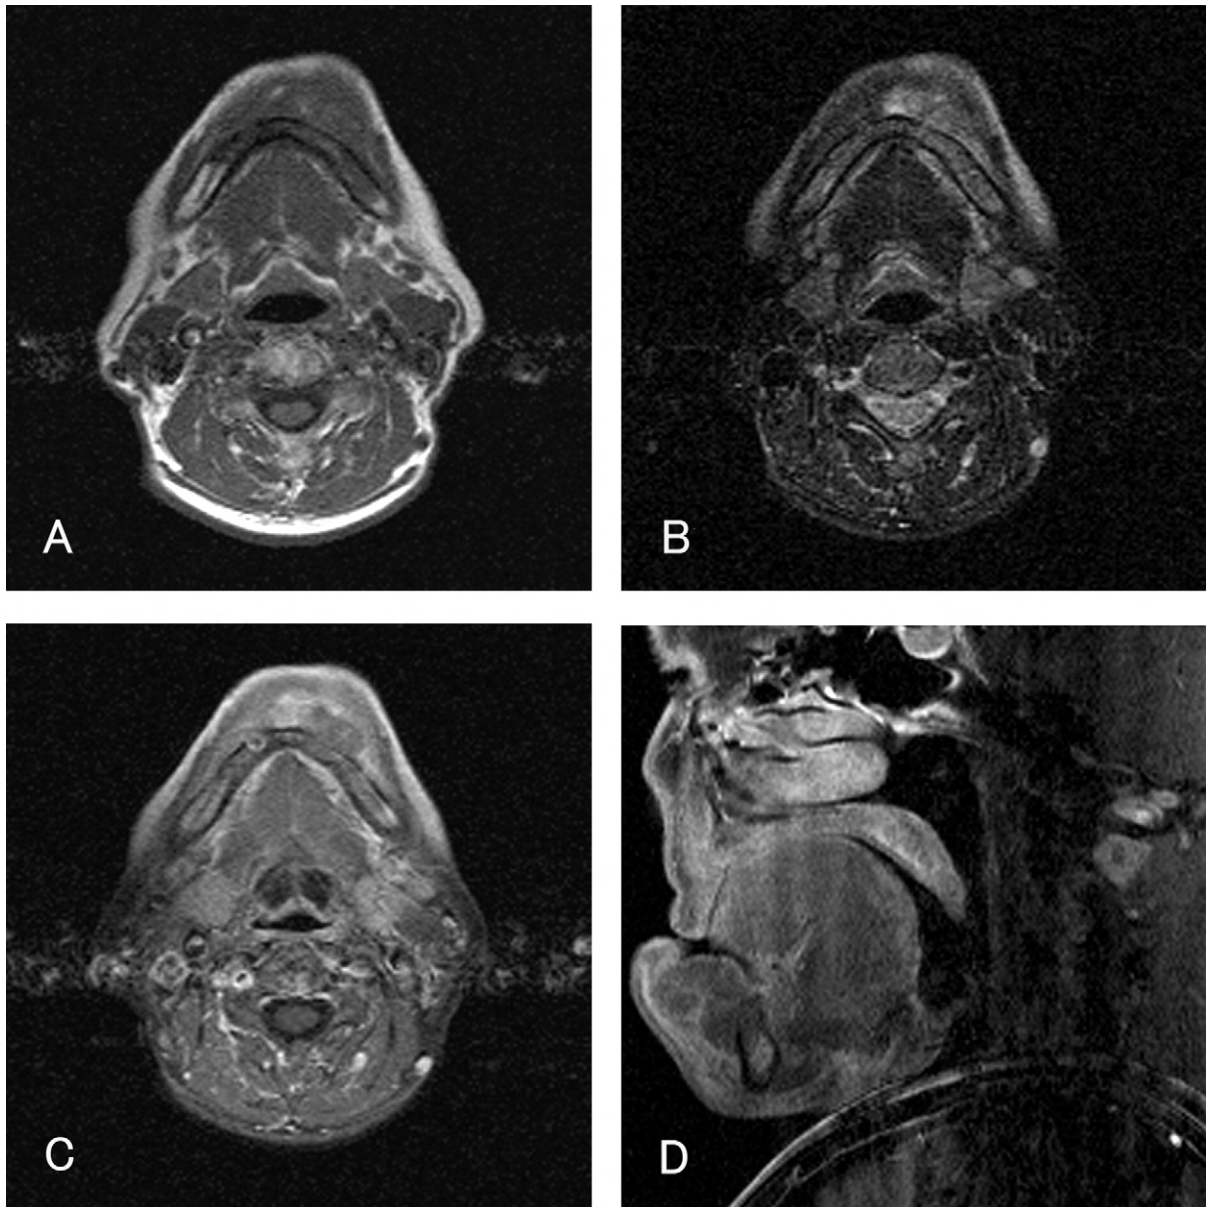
A, The lesion showed low signal intensity on T1-weighted magnetic resonance (MR) imaging (400/9 TR/TE) at initial examination. B, The lesion showed moderate intensity on T2-weighted fat-saturated imaging (3,500/99 TR/TE) at initial examination. C, In axial T1-weighted enhanced fat-saturated imaging (500/9 TR/TE), the lesion showed slight enhancement at initial examination. D, Sagittal T1-weighted enhanced fat-saturated image (500/10 TR/TE) showed the extension of the mass at initial examination.
